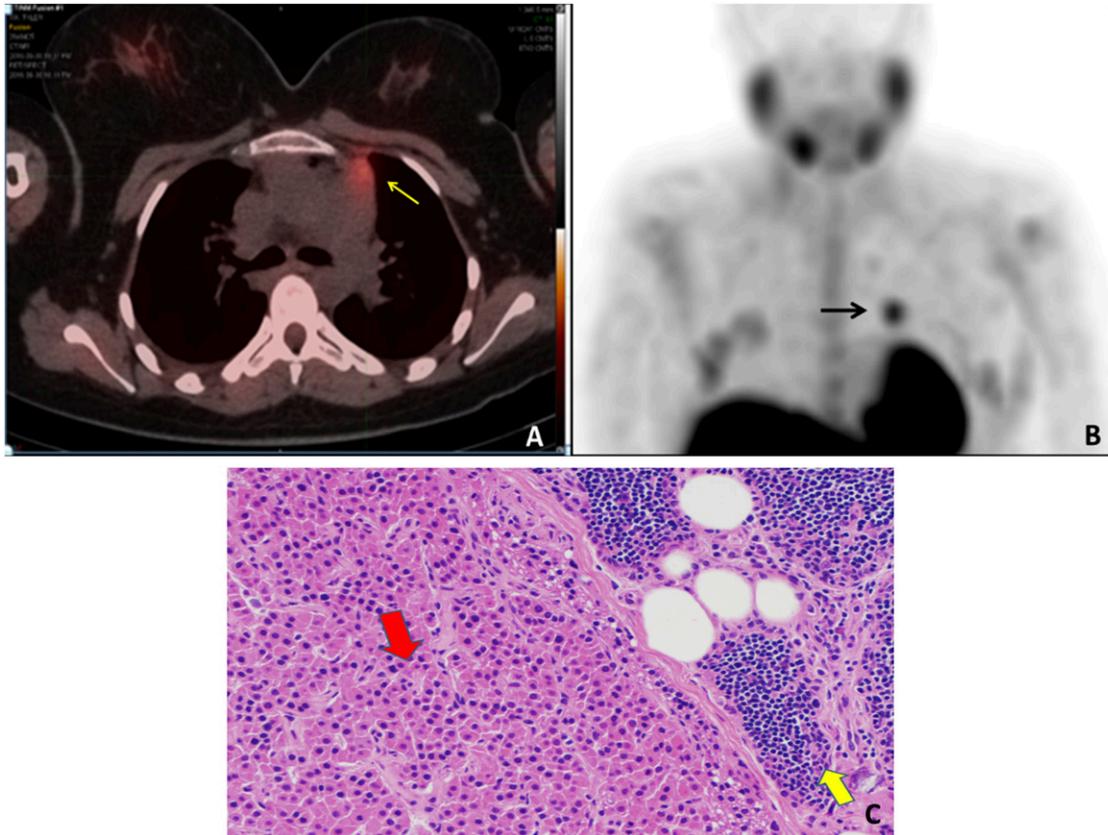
(A) Axial single photon emission computed tomography slice through the mid chest, with tracer activity in orange. The focus of intense activity in the left anterior mediastinum (yellow arrow) corresponds to the ectopic parathyroid adenoma, contiguous with thymus. (B) Maximal intensity projection image of the single photon emission computed tomography data. There is normal uptake of sestamibi in salivary glands, heart, liver, and lactating breasts. The round spot above the heart (black arrow) is abnormal and represents the patient's ectopic parathyroid adenoma. (C) Benign hypercellular parathyroid tissue (red arrow) with adjacent thymic tissue (yellow arrow) at total magnification of $\times 200$.
